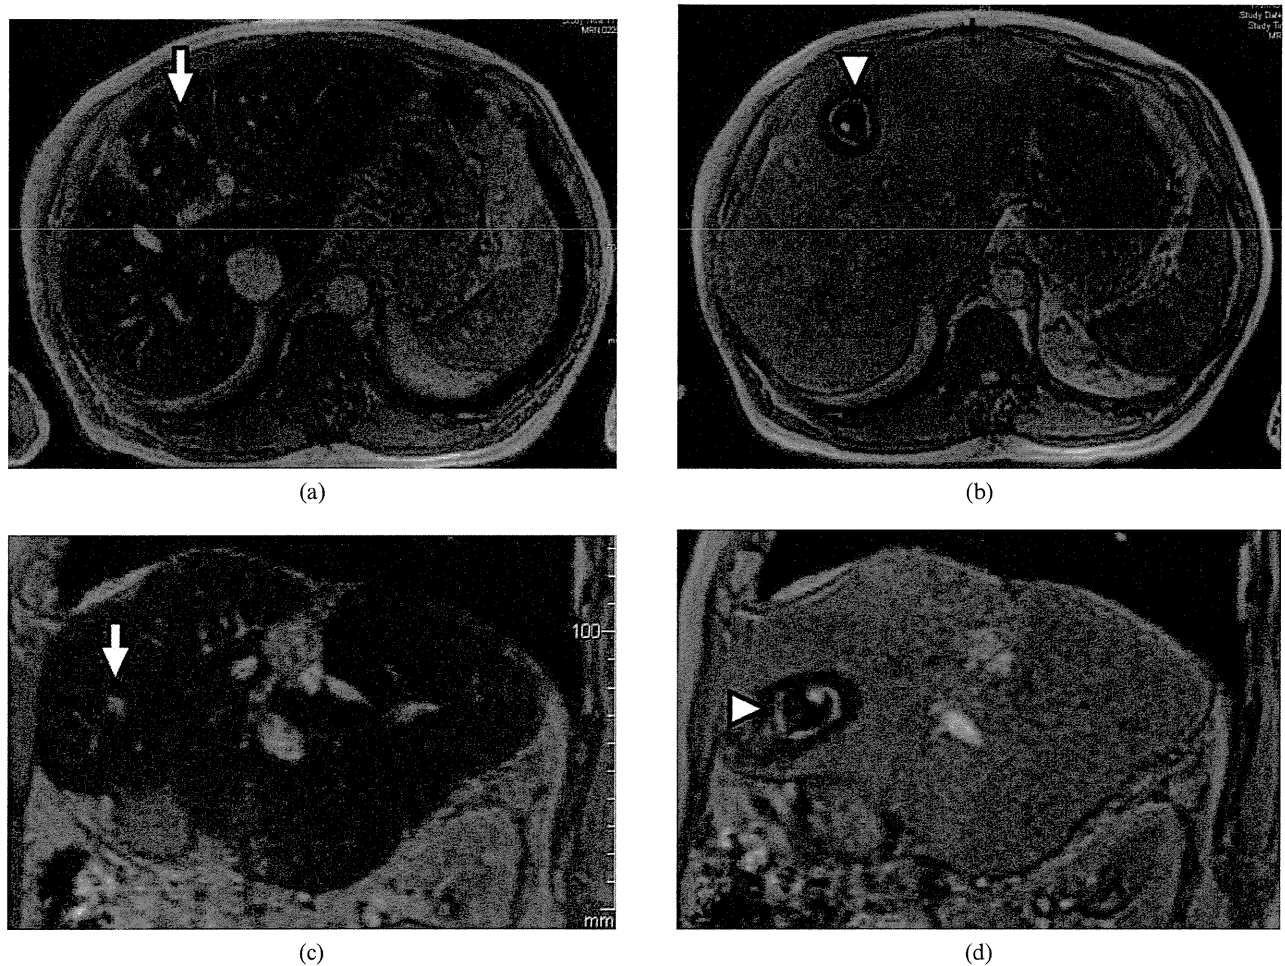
A 72-year-old male with an 8 mm hepatocellular carcinoma in liver segment V. (a) Transverse plane and (b) sagittal plane ferucarbotran-enhanced MRI before radiofrequency ablation (RFA) demonstrates a high-intensity tumour (arrow). (c) Transverse plane and (d) sagittal plane MRI after RFA shows three layers (low-high-low) around the index tumour. Part of the ablative margin was demonstrated to have become a high-intensity band (arrowhead).
